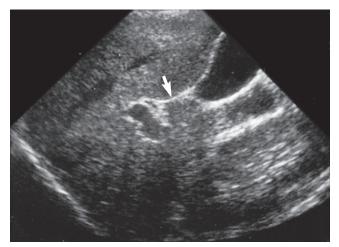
Longitudinal sonogram near the porta hepatis.
